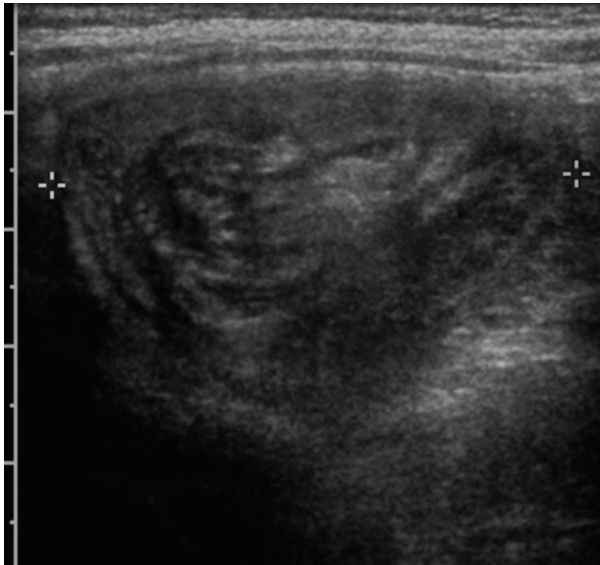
Ultrasound demonstrating the classical target sign in intussusception (Gaillard)*
